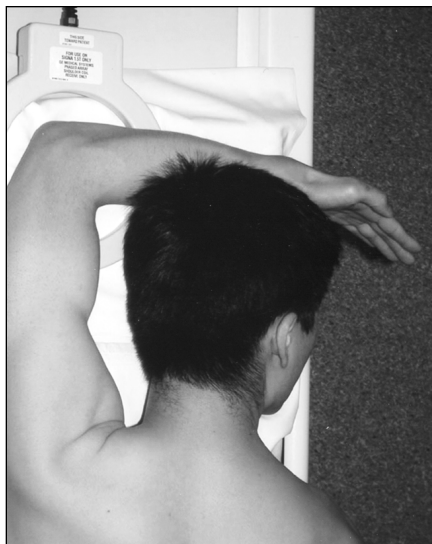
Photograph shows patient positioning for flexed abducted supinated view: patient is positioned prone on MRI table with elbow in flexed abducted supinated view position. Notice position of arm, flexed at elbow and abducted at shoulder with supinated forearm, thumb up.
